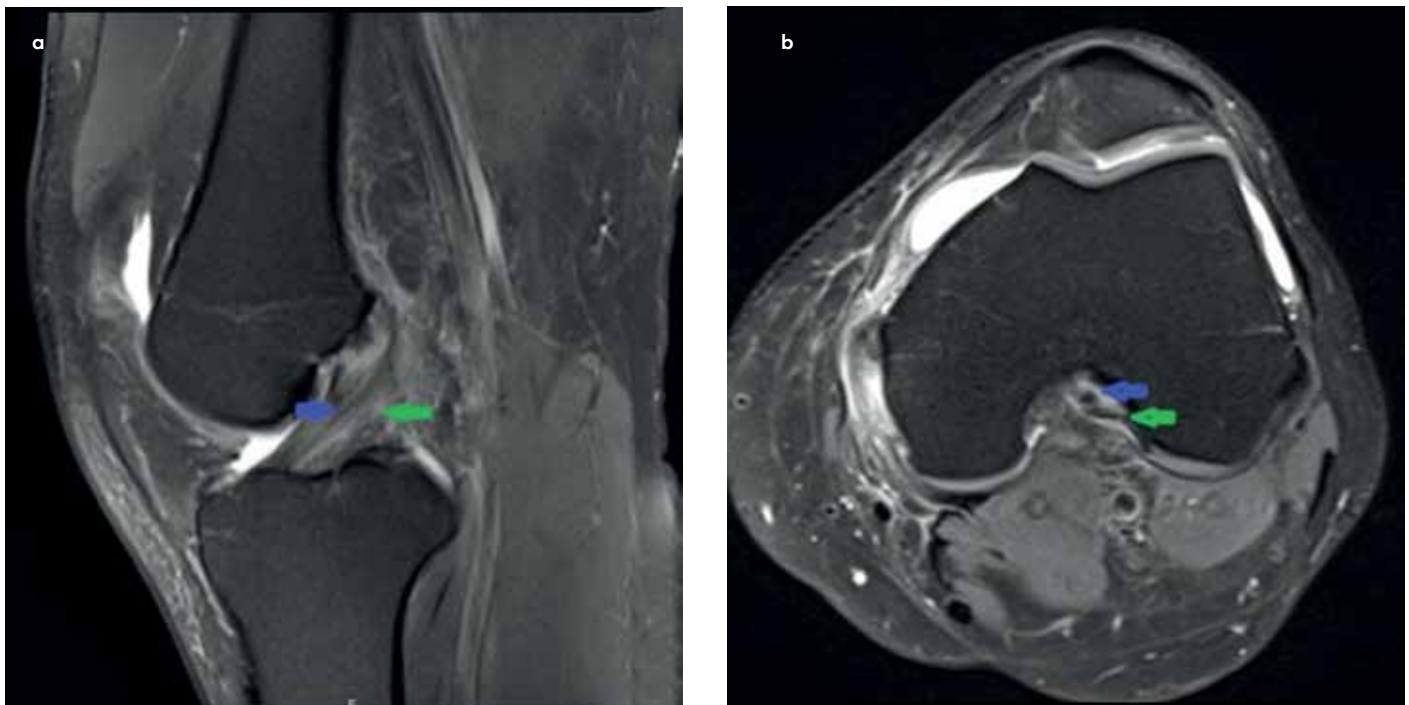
a, b. Sagittal proton-density MRI image of the knee: The blue arrow shows intact anteromedial bundle; the green arrow shows disrupted posteromedial bundle. (a) Axial proton-density MRI image of the knee: The blue arrow shows disrupted posterolateral bundle femoral attachment; the green arrow shows intact anteromedial bundle femoral attachment (b).
